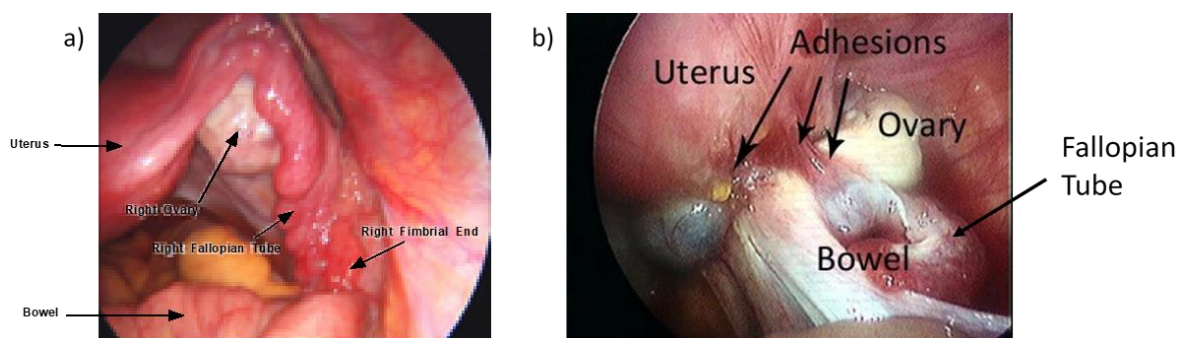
(a) Laparoscopic view of the normal right pelvic structures (image from "Dallas IVF" <https://www.dallasivf.com/fertility-treatment/infertility-surgery/>) (b) Laparoscopic view of right pelvic structures affected by adhesions from endometriosis (image from "Endometriosis Australia" <https://www.endometriosisaustralia.org/single-post/2016/09/03/Can-you-diagnose-Endometriosis-via-Ultrasound>)
